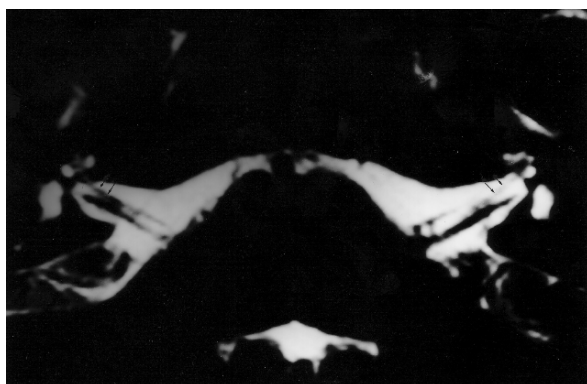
Axial 0.7mm T2 weighted MR image of IAM showing normal structures (arrow) (Normal subject)
